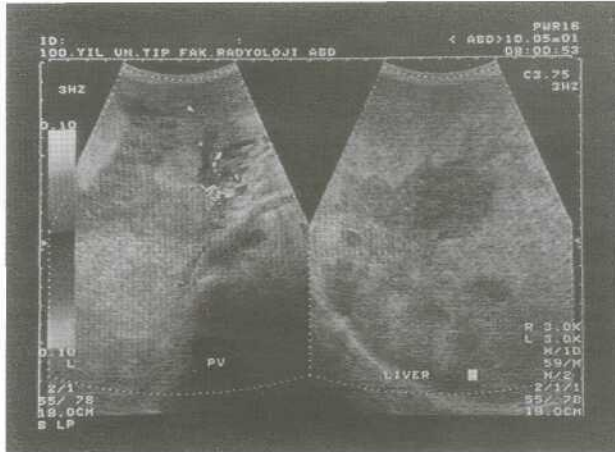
Color Doppler US revealed two giant masses in the liver causing cavernous transformation of the portal venous system in the hilar region of the liver.
